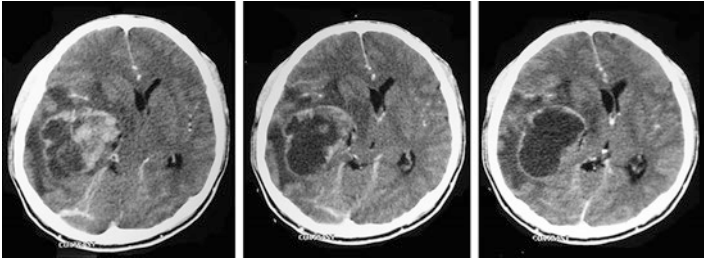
Contrast enhanced brain CT scan showing right temporal glioblastoma in a 21-year-old male with first grand mal seizure. Note the solid mass of enhancing tissue, the cystic non-enhancing core and the severe mass effect with effacement of the right lateral ventricle and midline shift. This requires urgent neurosurgical referral due to significant midline shift and brain compression
